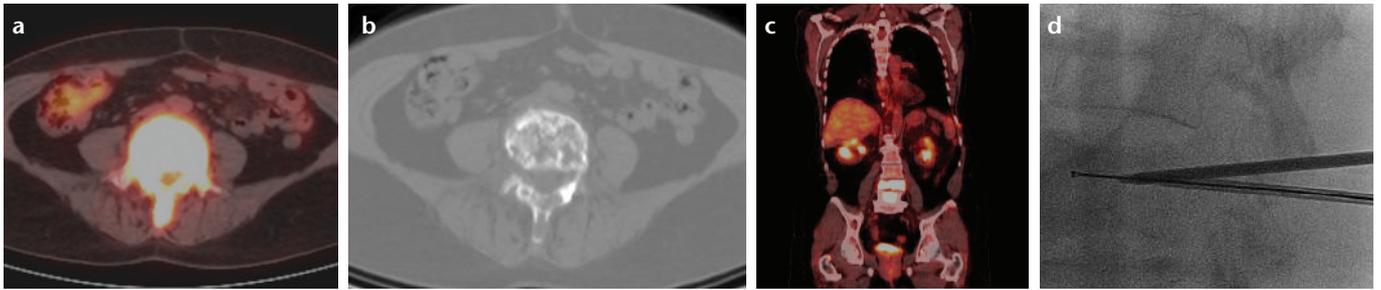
a–d. Images of a 65-year-old female with breast cancer and a metastatic vertebral fracture of L4 treated with coblation and vertebroplasty via a bipedicular approach. Axial (a, b) and coronal (c) preprocedure PET/CT images demonstrate a metastatic compression fracture involving L4. A lateral fluoroscopy image (d) of bilaterally placed coaxial systems with the coblation wand extending from one. Needles were advanced through the target pedicles. Optimal positioning of the 11-gauge access needle close to the midline within the anterior third of the vertebral body was confirmed.
